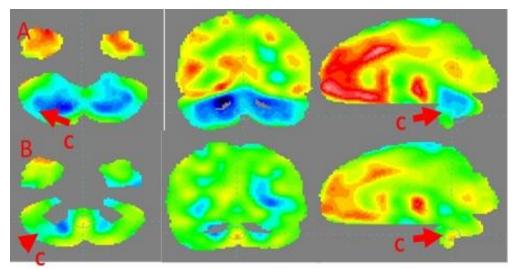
FDG-PET/CT image of a sensory ataxia patient showing reduction of hypometabolism in bilateral cerebellum (C). The images were normalized to the SCENIUM normal healthy brain volumetric template. (A) PET image before cellular therapy showed reduced metabolism in bilateral cerebellum (Blue – severe damage, yellow-green - normal) (B) PET image of six months after cellular therapy showed improved metabolism in bilateral cerebellum
